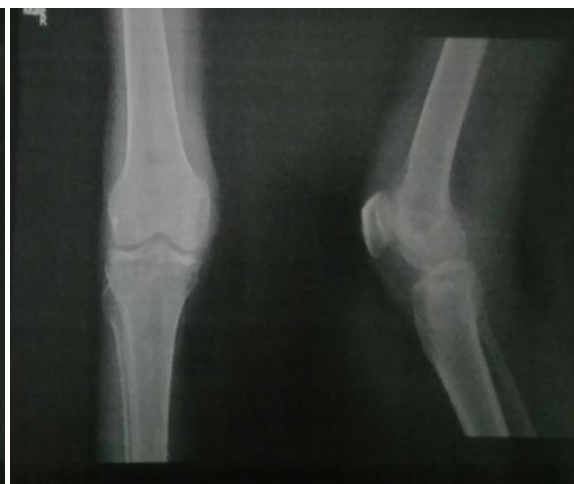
Post Procedure X-ray
